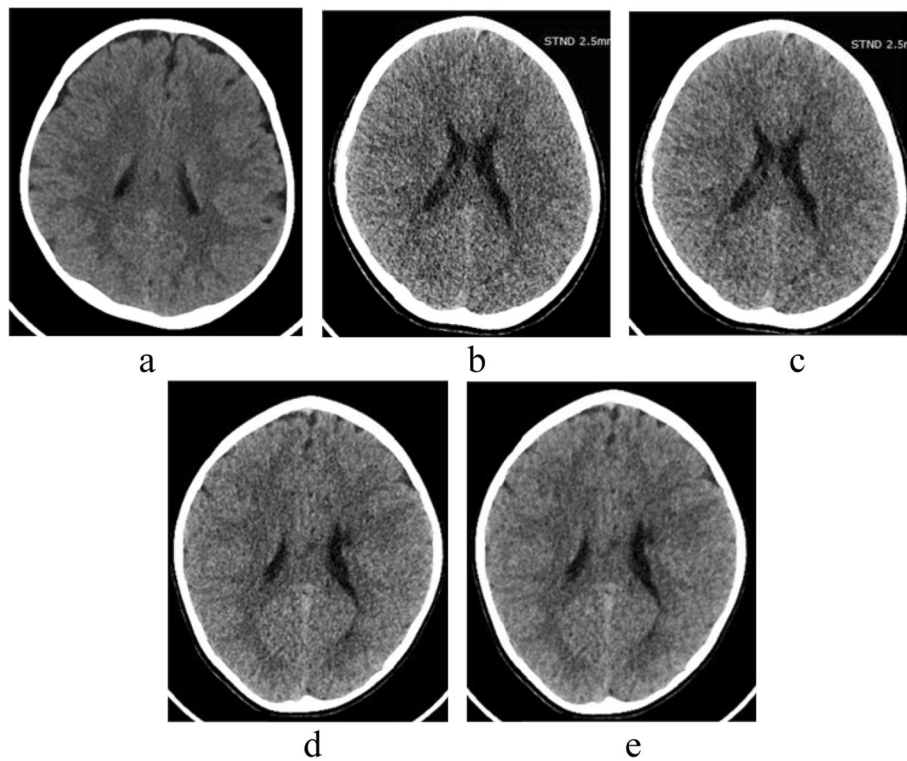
Image quality of CT images at the level of corona radiata. Non-ASIR CT image (a), 60% ASIR-V (b), and 80% ASIR-V (c) CT images using 40-mA tube current reduced CT protocol, and 60% ASIR-V (d) and 80% ASIR-V (e) CT images using 60-mA tube current reduced CT protocol
